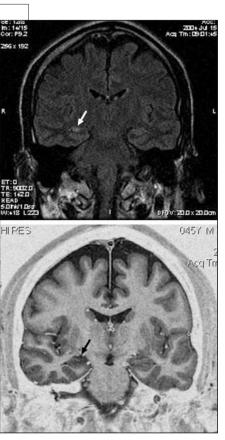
Top: Coronal section of MRI of the brain on FLAIR (fluid-attenuated inversion recovery) sequence, showing high signal changes in the right hippocampus (arrow). Bottom: Coronal section of the same MRI on IR (inversion recovery) sequence, showing evidence of atrophy of the right hippocampus (arrow). The combination of these findings is diagnostic of mesial temporal sclerosis.
